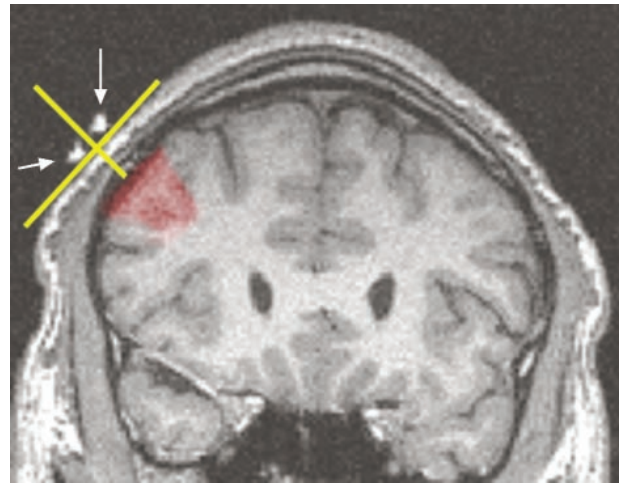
Coronal anatomical MRI of a representative subject, showing the site at which rTMS was delivered to target the dorsolateral prefrontal cortex. On the left-hand side of the image, above the skull can be seen the stereotactic marker used (arrows). In this coronal cut the marker appears in two parts due to its ring shape. The marker was applied to the subject's scalp position that was directly under the center of the coil during stimulation. The tangent to the scalp at this location and a perpendicular line to it are drawn in. As can be seen, the center of the stereotactic marker projects directly above the middle frontal gyrus and rostrally enough to be targeting the dorsolateral prefrontal cortex.
